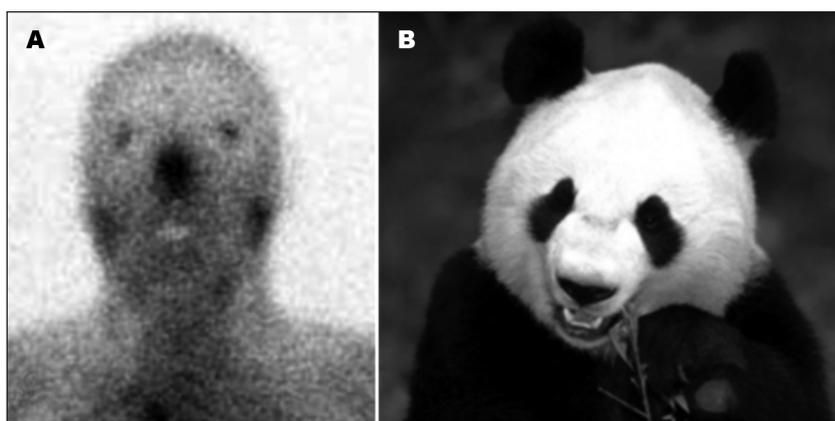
Galium-67 scintigraphy. Panda's sign due to simetric galium uptake in the parotid and lachrymal glands [A]. The pareidolic image resembles a panda bear [B].
